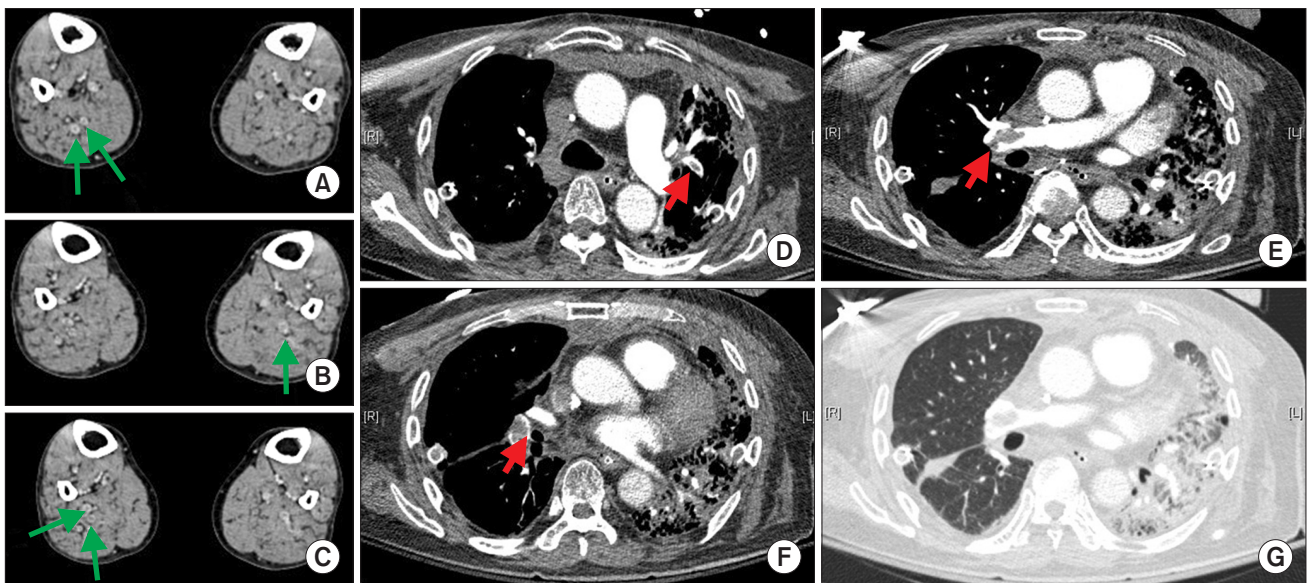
(A–G) A 58-year-old male patient who underwent lung transplantation due to idiopathic pulmonary fibrosis. At 10 days post-lung transplantation, a chest spiral computed tomography (CT) scan and leg extremity CT scan showed deep vein thrombosis and pulmonary thromboembolism (arrows).
